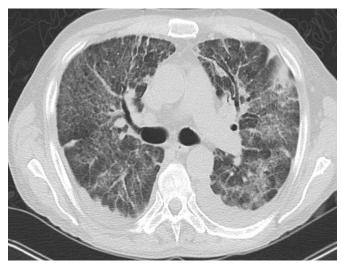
Axial chest computed tomography showing interval development of overtly abnormal patchy interstitial alveolar airspace disease within mid-upper lung predominance, along with small bilateral pleural effusions.
